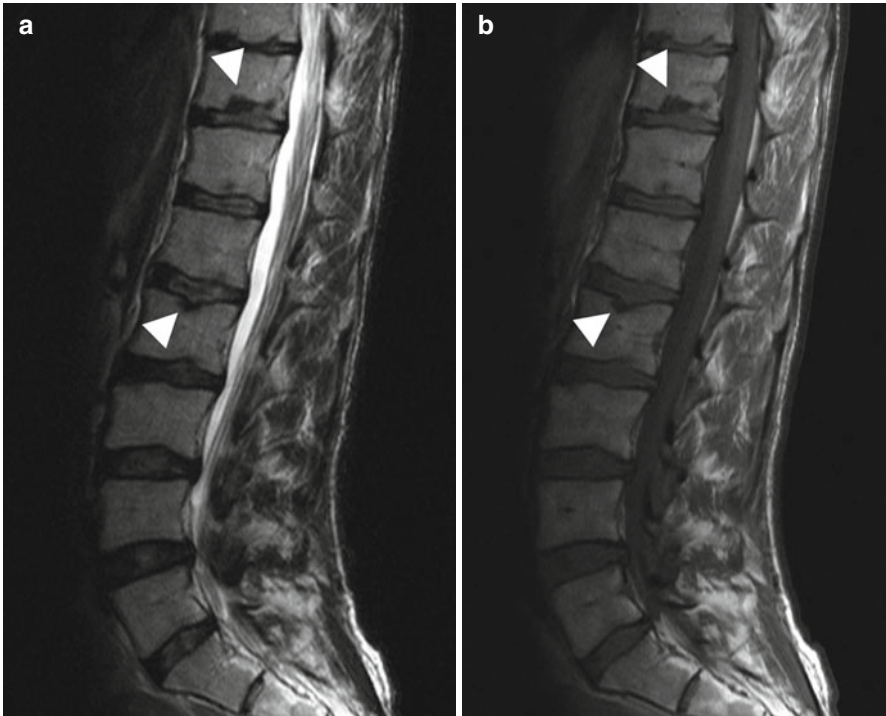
Typical late sequelae of Scheuermann disease in a 50-year-old woman. Multiple Schmorl nodules (*arrowheads*), predominantly involving the lower thoracic and upper lumbar spine, and loss of lumbar lordosis due to decrease in anterior vertebral body height on sagittal T2w TSE image (a) and sagittal T1w TSE image (b). MRI shows no acute changes, and the woman had no complaints in this region
